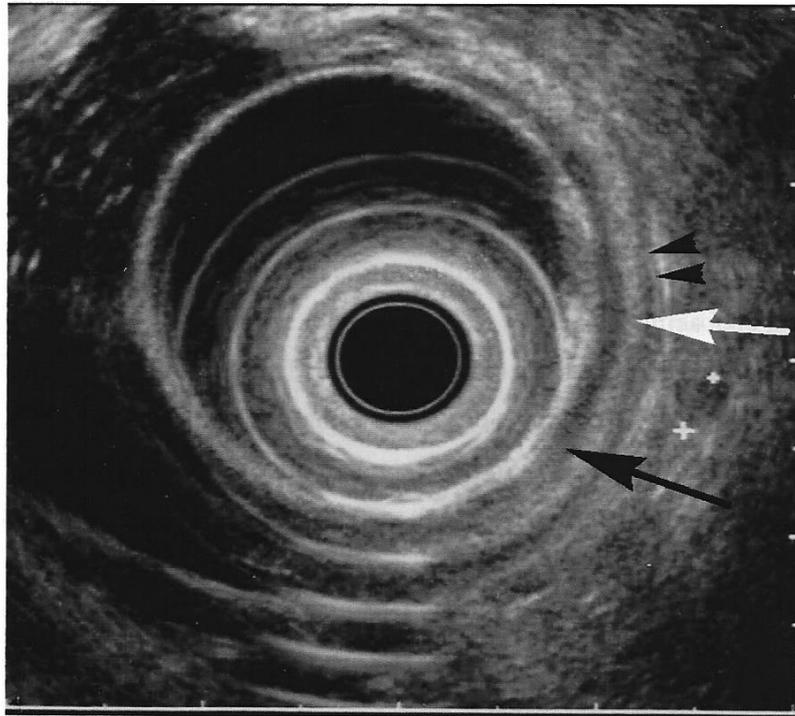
Selected radial endoscopic ultrasound image demonstrating different layers of the oesophageal wall. The inner hypoechoic layer (black arrow) represents the muscularis mucosa and the middle hyperechoic layer (white arrow) represents the submucosa. The outer hypoechoic layer (black arrowheads) represents the muscularis propria. A small, hypoechoic lymph node is marked with calipers. The image was acquired in the distal oesophagus at 36 cm using a UM-2000 Olympus Video EUS endoscope (Key Med, Southend, UK).
